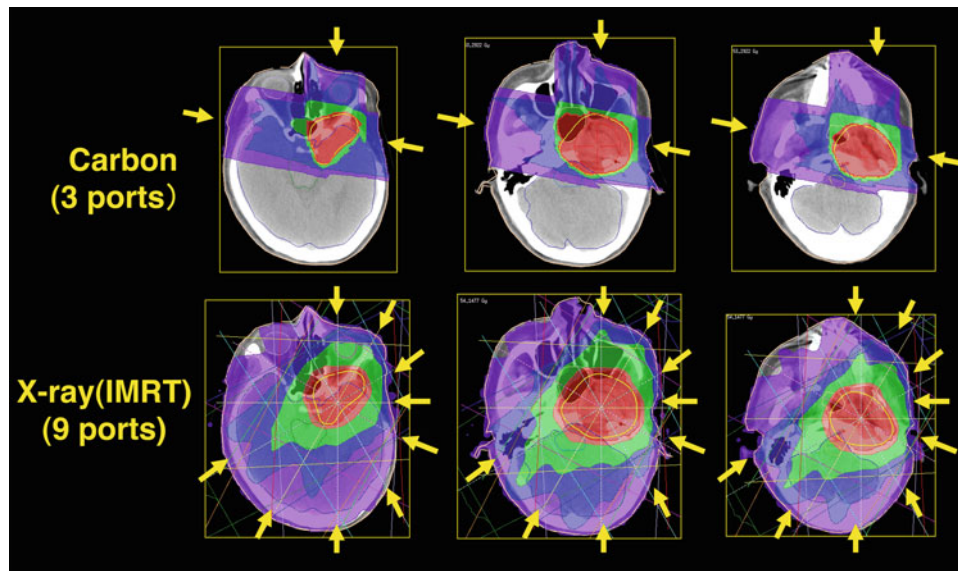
The dose distribution of IMRT using X-rays (*left*) and carbon ion beams (*right*). Carbon ion beams could produce a more conformal dose distribution and steeper dose gradients without an increase
